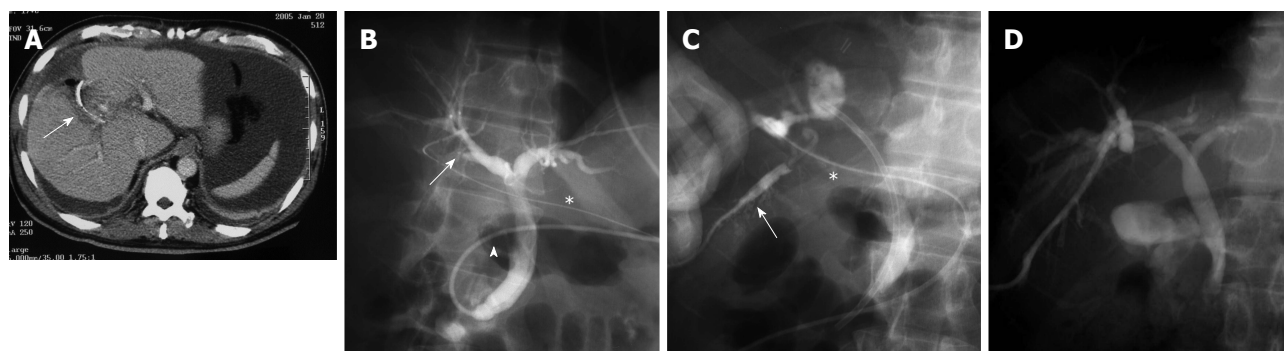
A 65-year-old man who had undergone segment 5 resection and radiofrequency ablation in segment 1 for hepatocellular carcinoma presented with bile leakage after surgery. A: Computed tomography shows non-dilated intrahepatic bile ducts and an intraperitoneal drainage tube (arrow) placed at the time of surgery; B: Cholangiogram via the endoscopic nasobiliary drainage tube (arrowhead) reveals stricture of the posterior sectional bile duct (arrow). Asterisk shows the intraperitoneal drain placed at the time of surgery; C: Non-dilated peripheral B6 (arrow) is punctured with a 21-G needle. Asterisk shows the intraperitoneal drain placed at the time of surgery; D: An 8-Fr biliary drainage tube is advanced through the strictured right posterior sectional bile duct and placed from B6 to the common bile duct.
